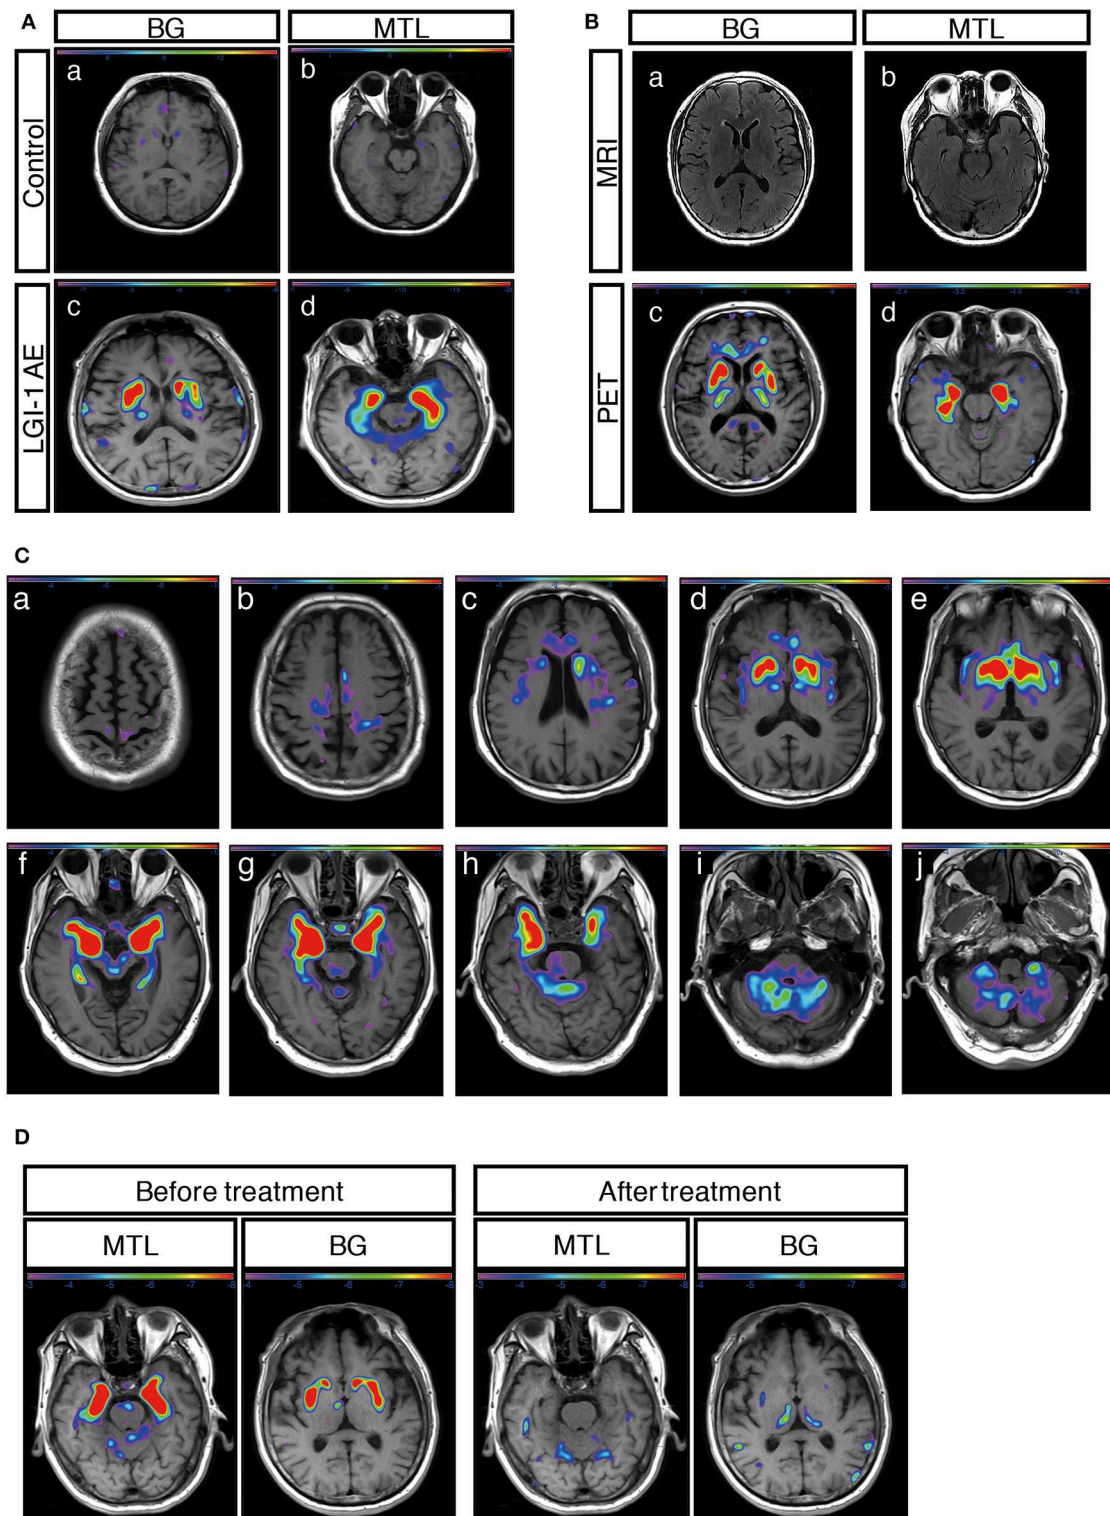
^{18}F -FDG-PET metabolic pattern in patients with LGI1 AE. (A) Typical BG and MTL hypermetabolism based on ^{18}F -FDG-PET in patients with LGI1 AE. Age-matched control patients with colorectal cancer in the absence of central nervous system lesions indicating healthy metabolism in the BG (a) and MTL (b). Representative increased metabolism in the BG (c) and MTL (d) in a patient with LGI1 AE. (B) MRI-negative and PET-positive metabolic patterns in LGI1 AE subjects. The axial fluid-attenuated inversion recovery image indicates a normal signal in the BG (a) and MTL (b), whereas ^{18}F -FDG-PET reveals hypermetabolism in the identical location from the same patient with LGI1 AE (c,d). (C) The brain sequences in ^{18}F -FDG-PET with LGI1 AE patients. Total brain ^{18}F -FDG-PET mapping indicates the (Continued)
